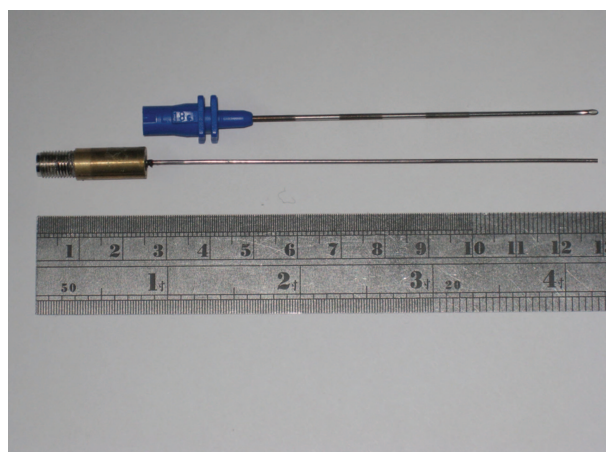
The needle ultrasound transducer and the epidural needle are shown. The epidural needle (blue handle) is a standard 10-cm, 18-gauge Tuohy needle.
